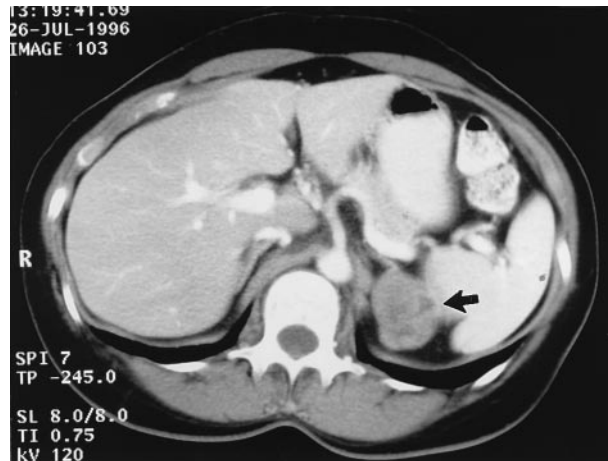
Abdominal computed tomographic scan after administration of oral and intravenous contrast reveals a left adrenal mass (arrow). No other evidence of intraperitoneal metastases was noted.
